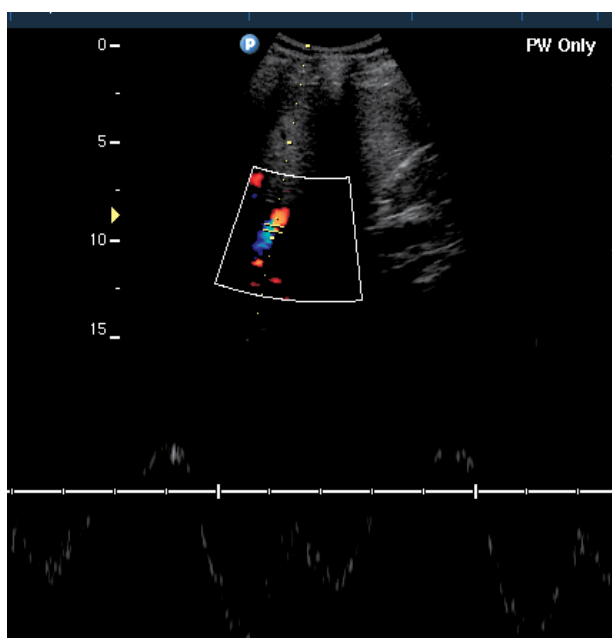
Triphasic VHDx Doppler waveform in 29 y.o. patient with mild (Knodell F1) liver fibrosis and without liver steatosis (S-0).
